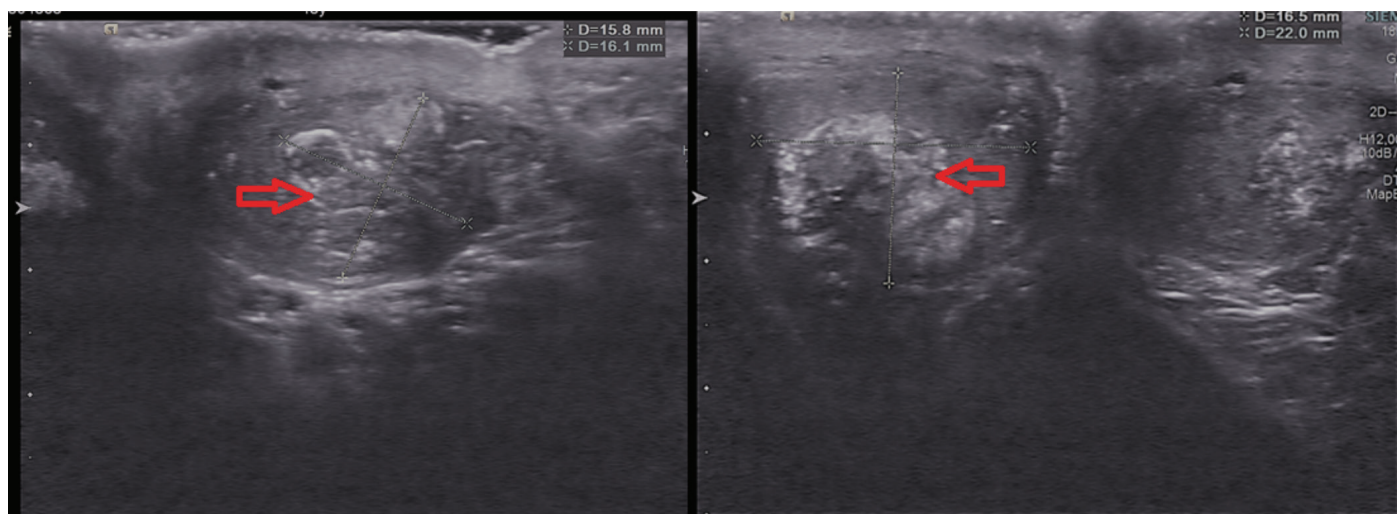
a) Ultrasonography image of the right testicle showing a hypoechoic mass, b) Ultrasonography image of the left testicle showing a hypoechoic mass
